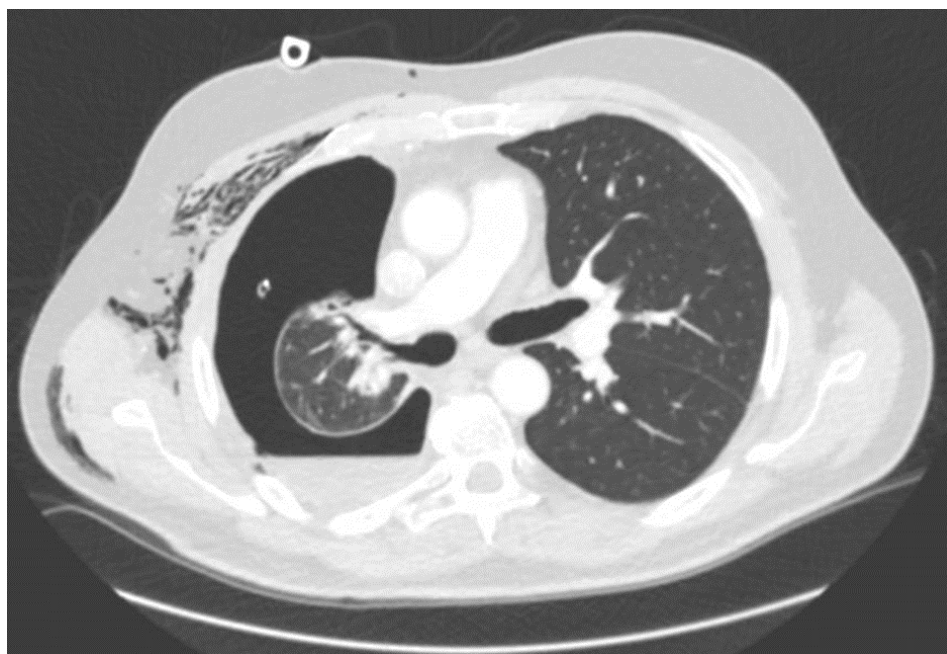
CT-scan showing large pneumothorax, pleural thickening and small BPF of RUL communicating with residual pleural space
